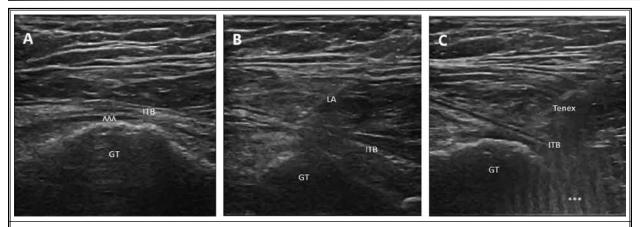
(A-C): (A) ^^ Diseased tissue at the musculotendinous junction of the ITB. Note that the TENEX needle is approaching from the caudal-to-cranial direction. (B) 25-G needle introducing local anesthetic at the diseased site. (C) TENEX needle introduced with typical noise artifact seen on the US screen when the US energy is deployed (*). ITB, iliotibial band; US, ultrasound.
